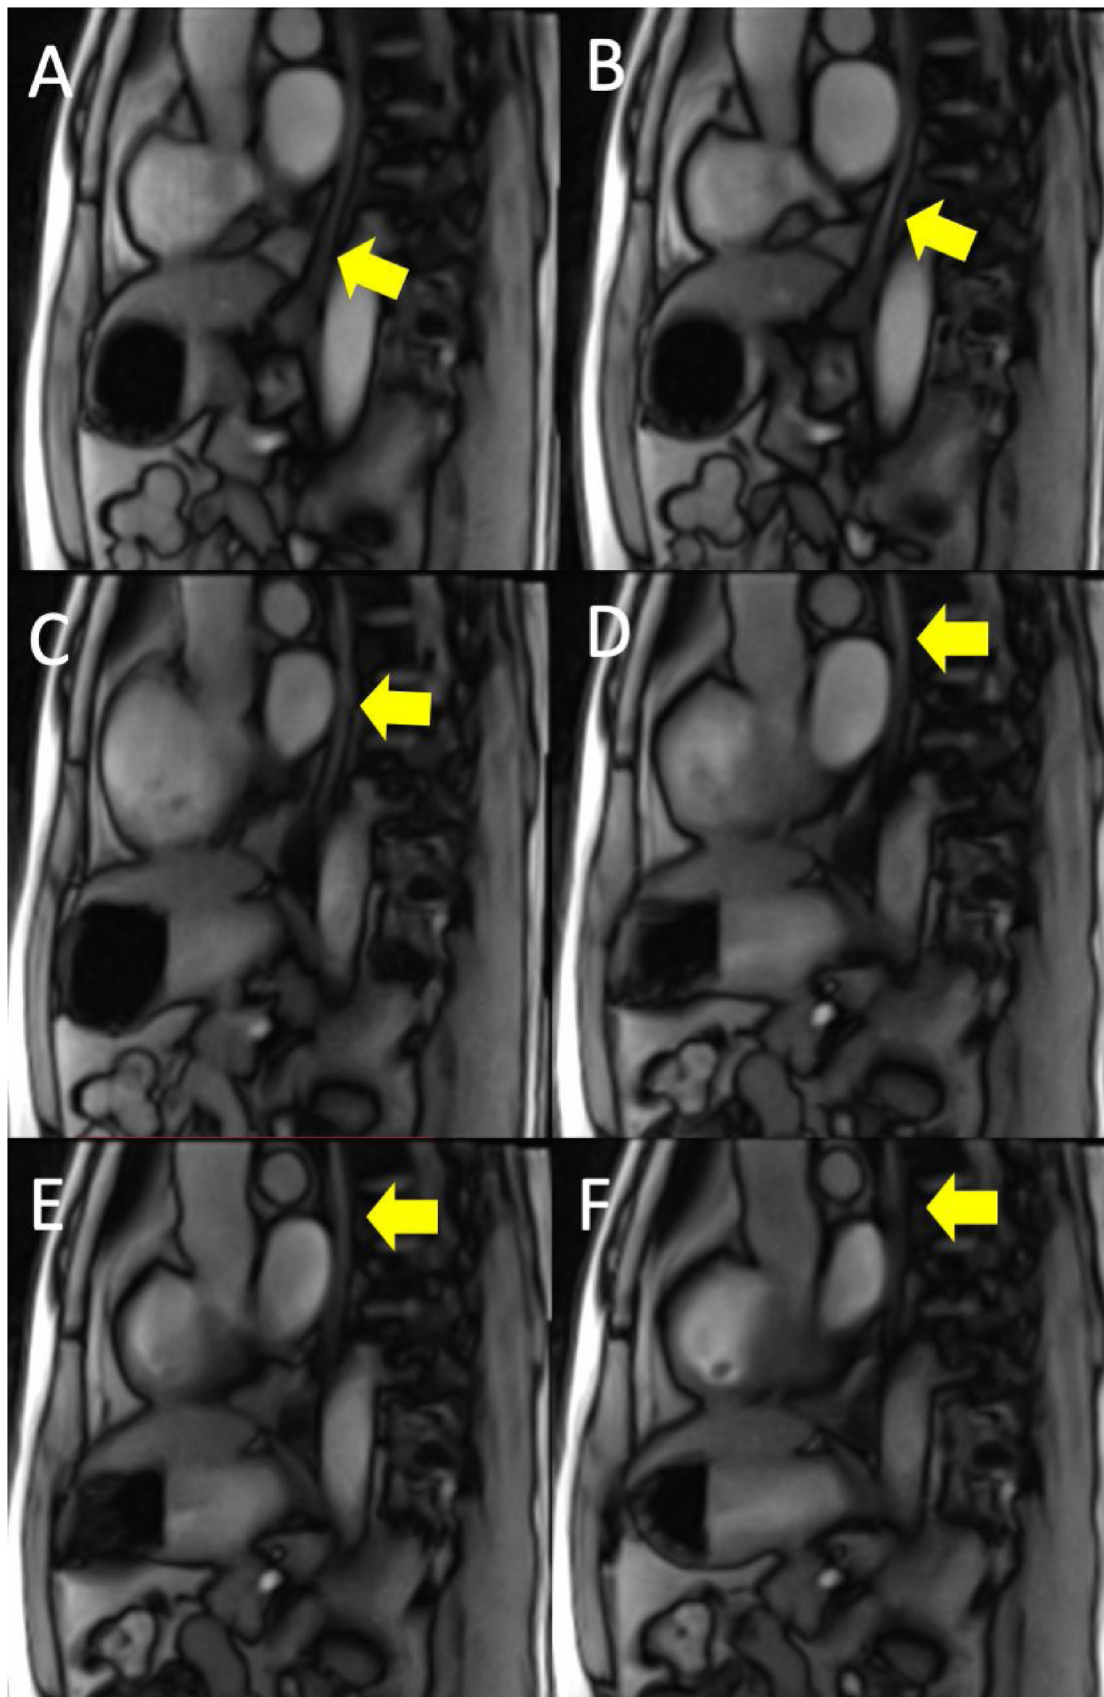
Real-time MRI of the LES during Valsalva maneuver in sagittal planes. Case 2 depicts a subject with reflux on real-time MRI, pH-metry and impedance. Representative individual images were selected showing instant reflux before and after Valsalva maneuver was performed. Also see supplemental Video 2.
